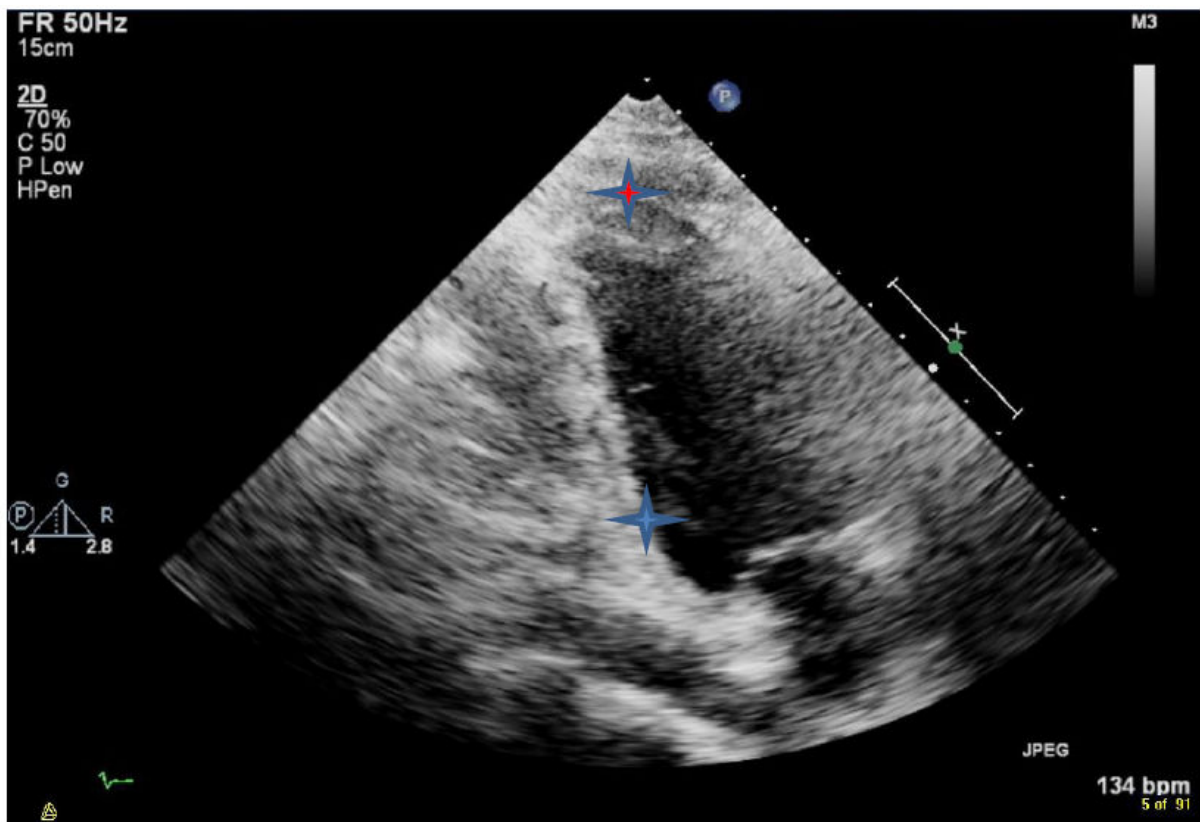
Transthoracic Echocardiography two chamber view showed systolic phase of left ventricle. Apical wall was collapsed for contractile movement (See red star), however, hypokinesis of Inferior basal wall in the left ventricle was observed (See blue star).
